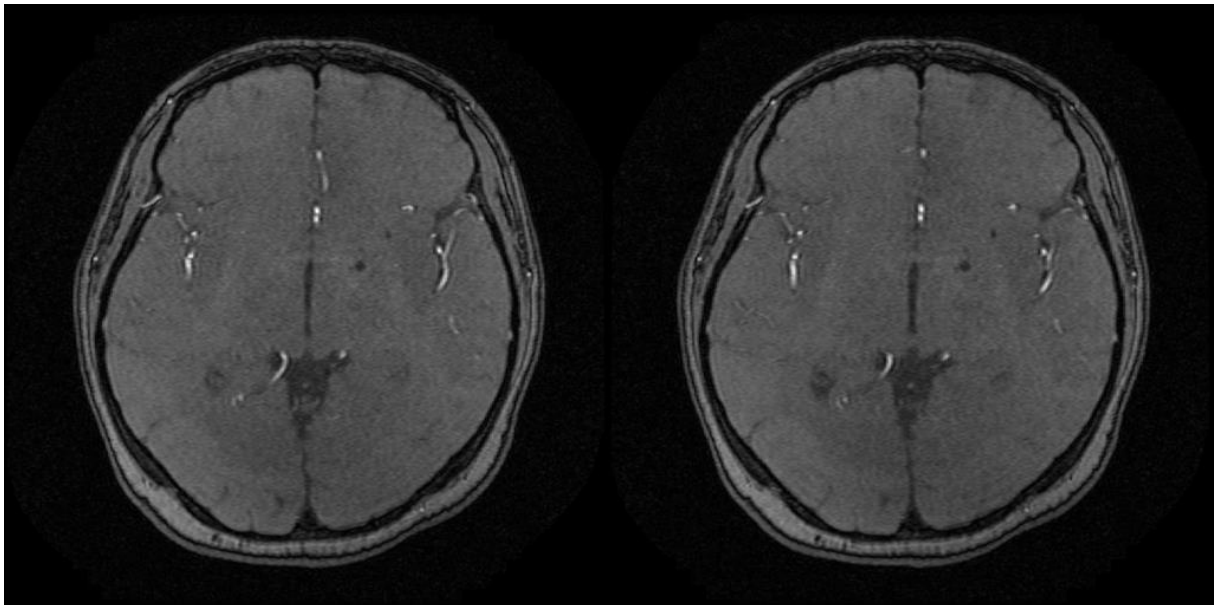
Patient's Magnetic Resonance Image
